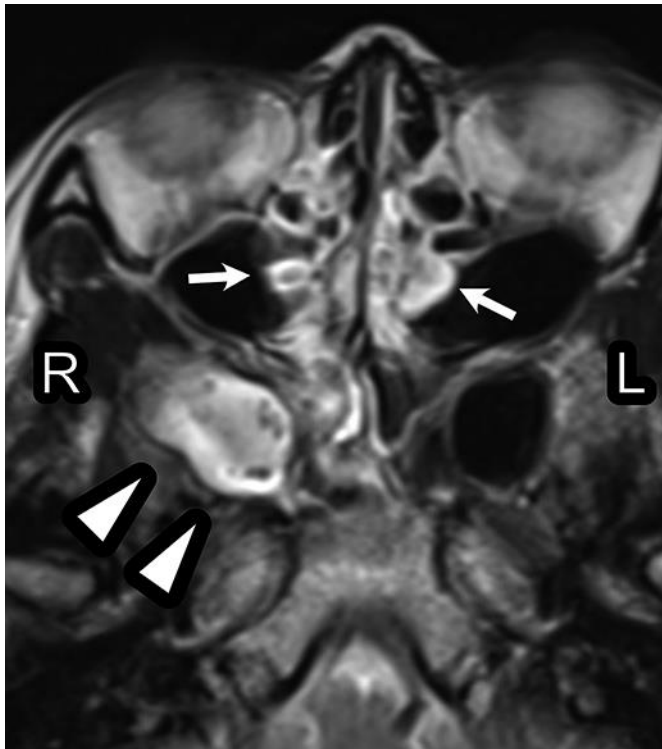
Axial T2-weighted follow-up MR image 1 month after onset. This MR image reveals chronic sinusitis of the right greater wing, which is filled with mucosa and fluid (arrowheads), and the ethmoid sinus, which has thick mucosa (arrows).
